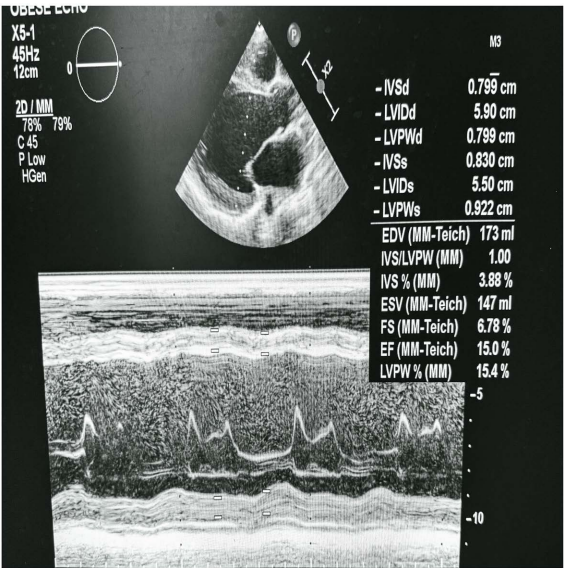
Transthoracic echocardiogram showing a dilated and hypokinetic left ventricle.
